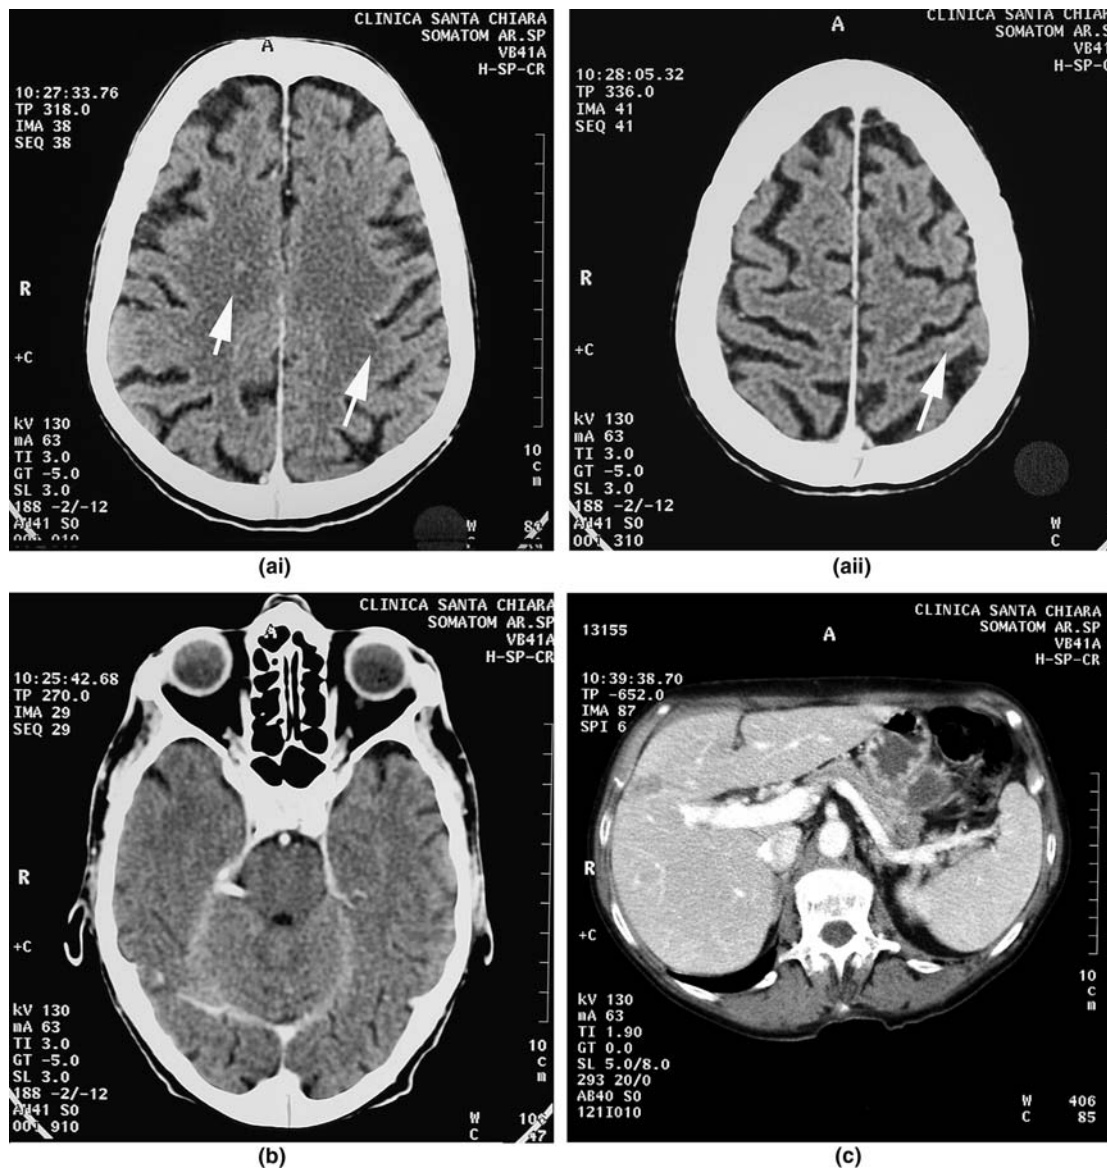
Computed tomography scan showing a significant reduction in (a) brain, (b) cerebellar, and (c) liver metastases.
